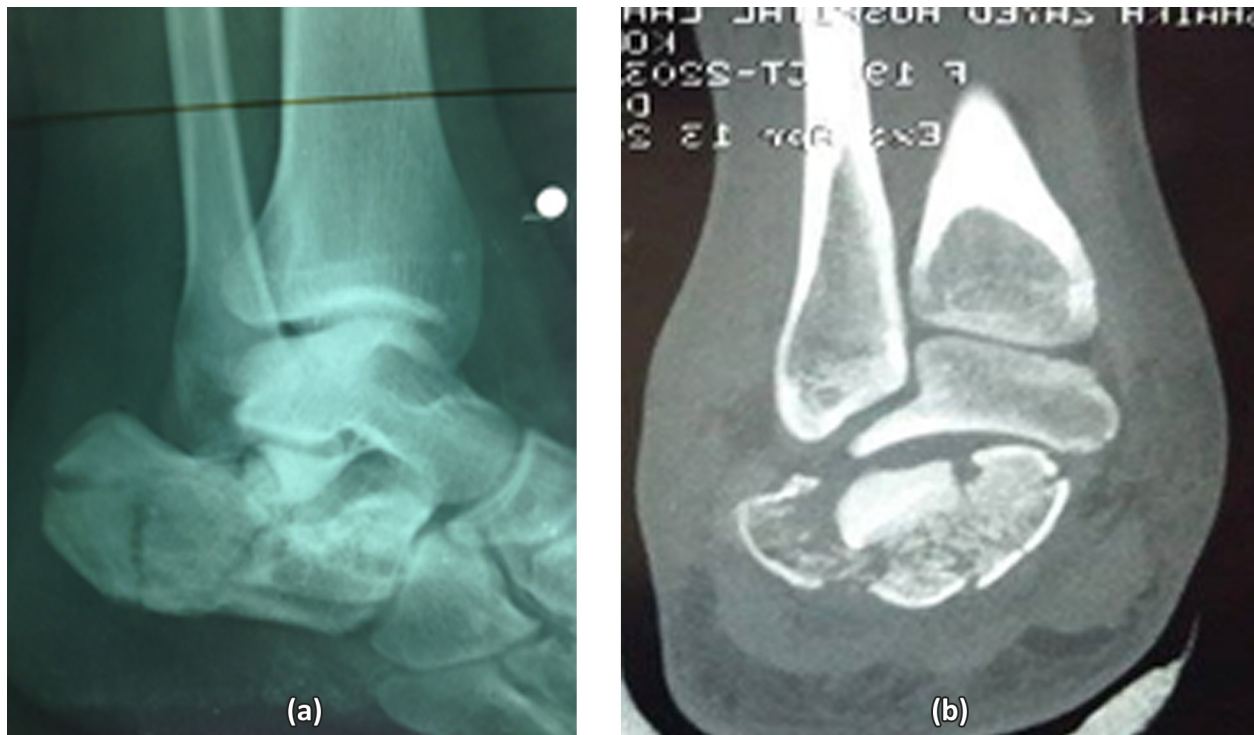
a, b: Preoperative X-ray, Preoperate CT scan
